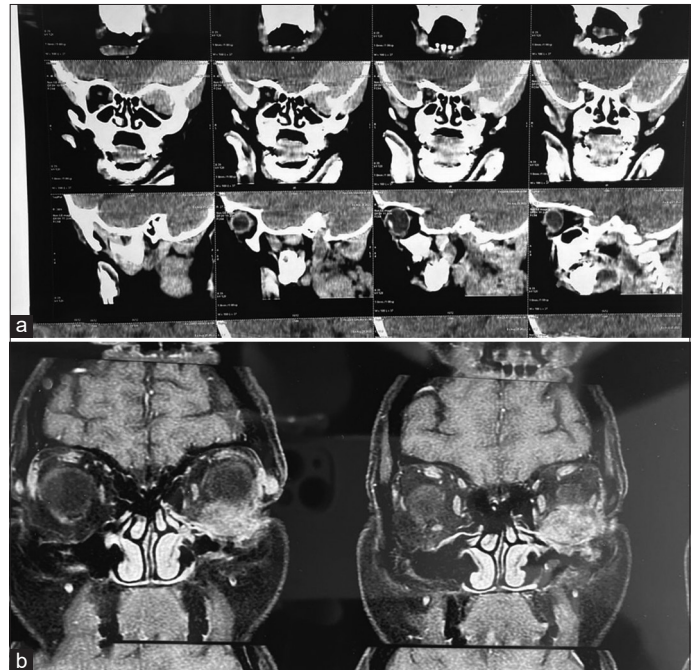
(a) Magnetic resource imaging (MRI) of head/neck and orbit neuroblastoma ill-defined iso-hypodense soft-tissue lesion noted extraconal involving superior lateral and superior rectus muscle causing bony erosion of roof and lateral wall orbit; (b) MRI of orbit mass of left infraorbital rim in carcinoma of breast metastasis. Moderate to intense enhancing mass lesion extraconal mass lesion inferior aspect left orbit, bone destruction, and extension to roof of maxillary bone
